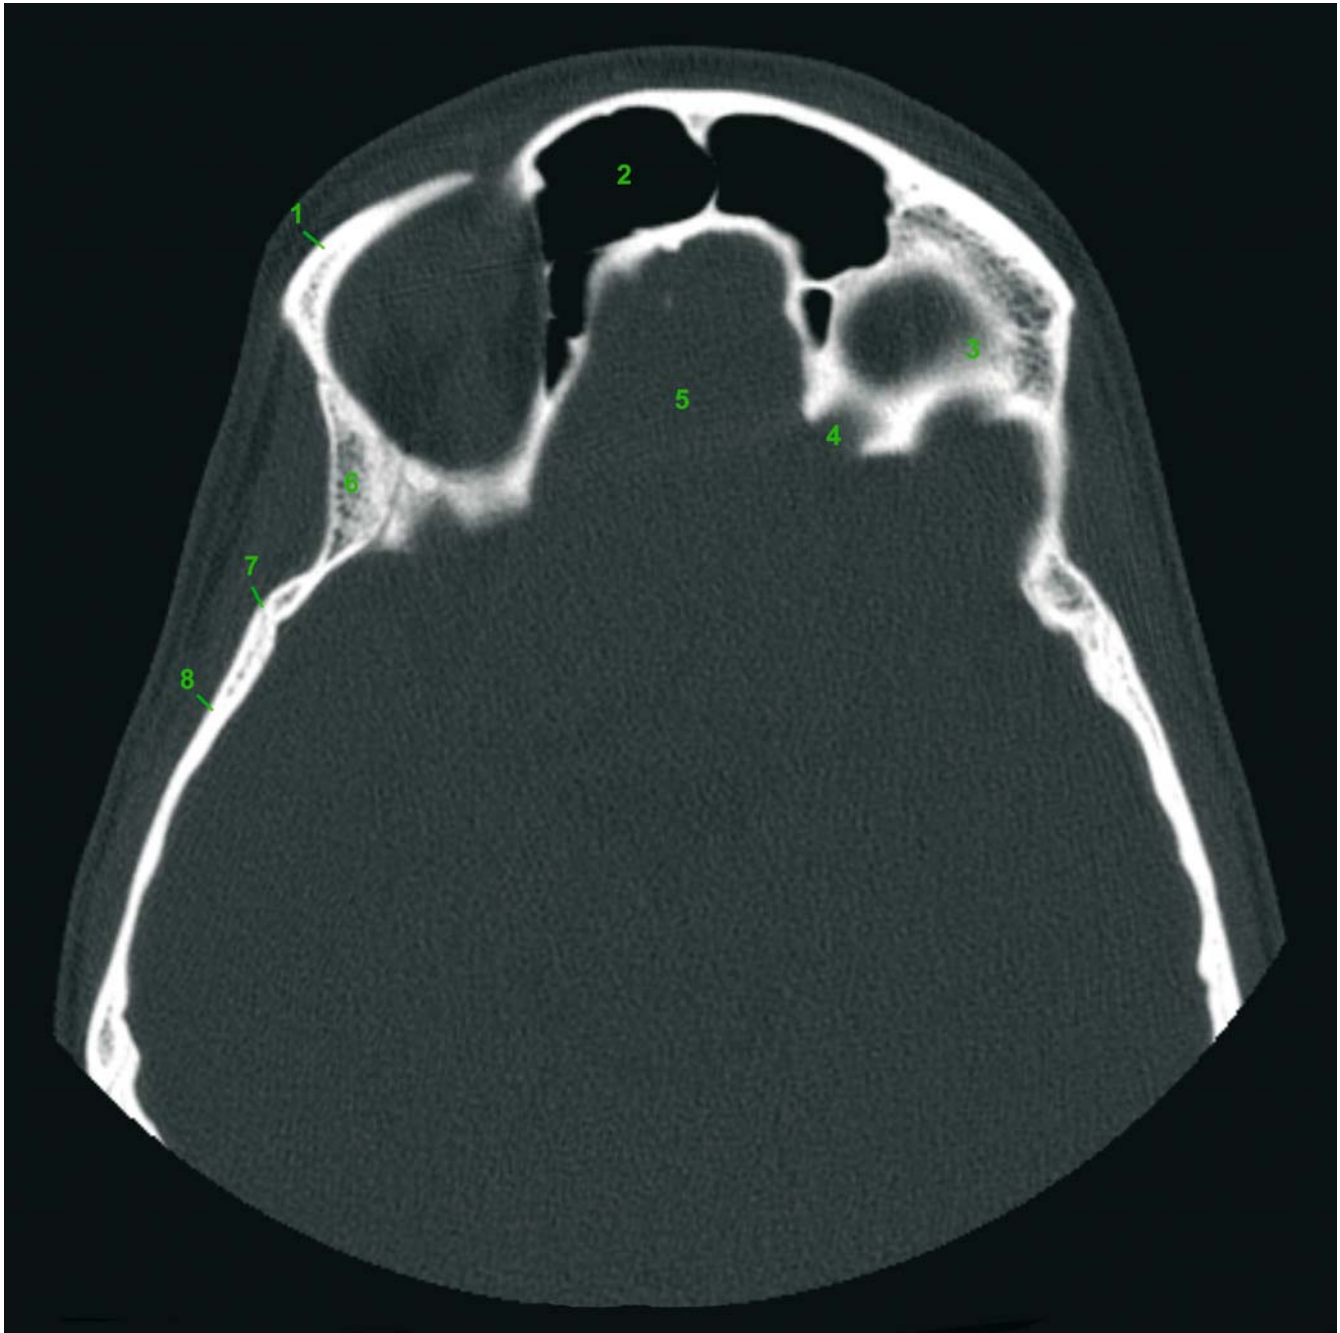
Axial CT slice 2 (patient K.C.). 1 Frontal bone; 2 Frontal sinus; 3 Orbital roof; 4 Optic canal; 5 Anterior cranial fossa; 6 Sphenoid bone; 7 Sphenosquamosal suture; 8 Temporal bone
